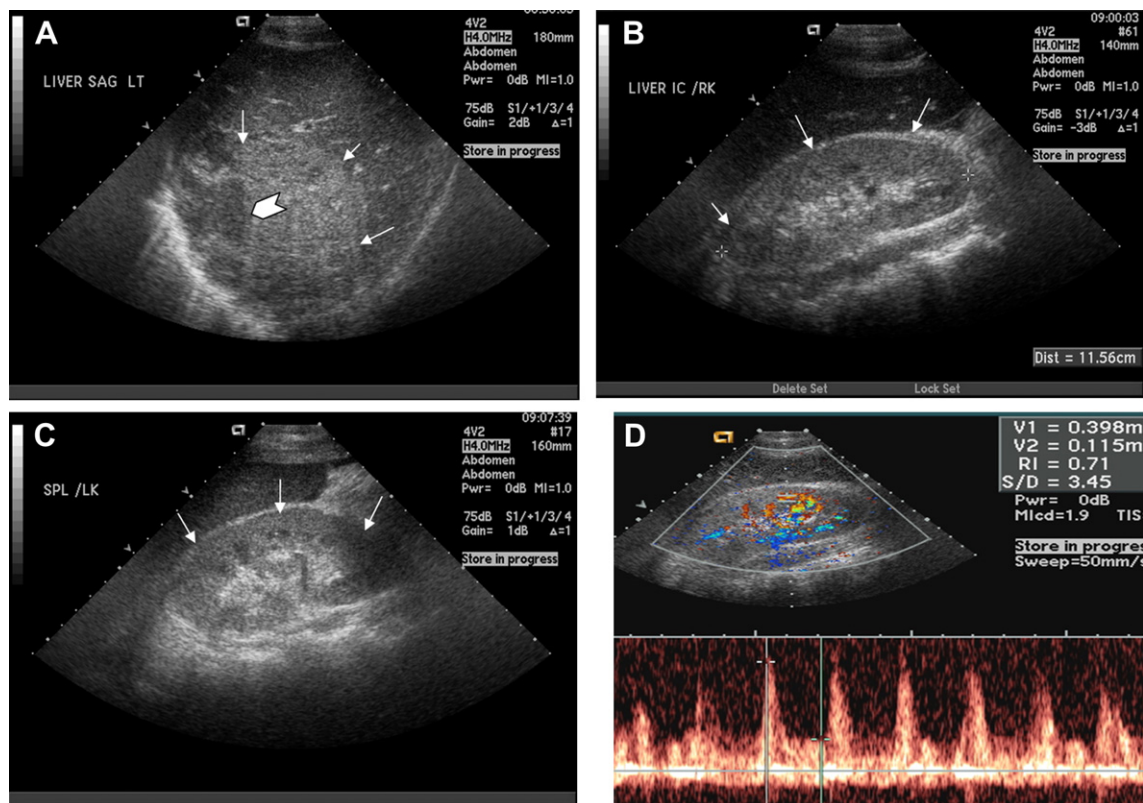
Ultrasonographic images of the liver and kidneys on admission. (A) A large abscess in the right lobe of the liver is noted, which was composed of echogenic parts (arrows) and liquefied fluid spaces (arrowhead). (B,C) Bilateral kidneys showing increased renal cortical echogenicity with increased corticomedullary differentiation (arrows). (D) Spectral Doppler study showing a peak flow of 39 cm/sec in the interlobar artery with a resistivity index of 0.71.
